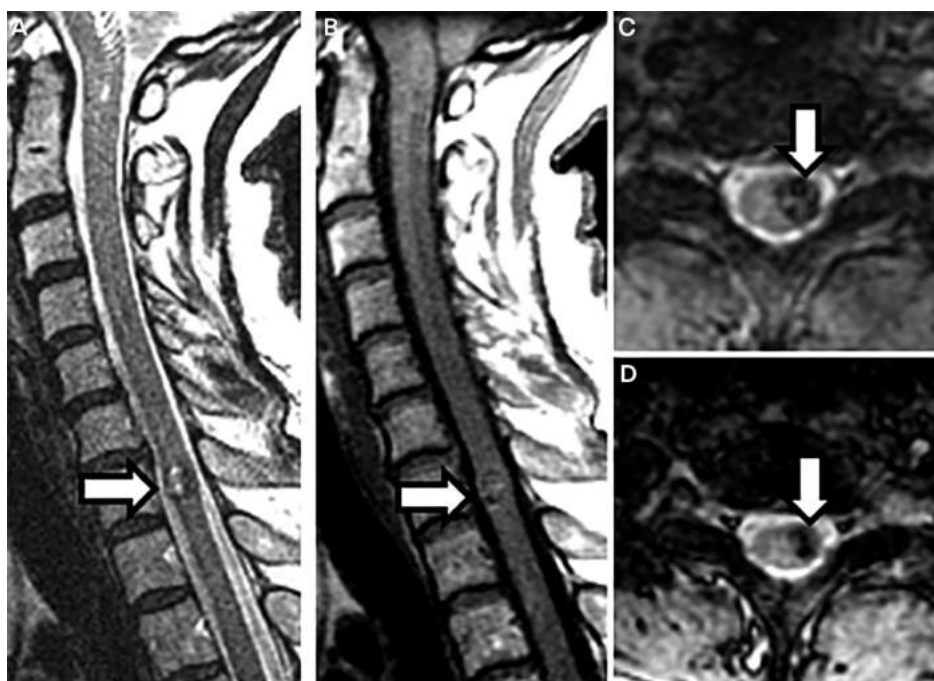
Imaging of the patient in CASE 2-3. Sagittal T2-weighted (A) and T1-weighted (B) MRI of the cervical spine shows hematomyelia with mixed T2 hypointensity (A, arrow) and T1 hyperintensity (B, arrow). Corresponding axial T2-weighted images (C, D) show a well-demarcated T2-hypointense rim (C, arrow; D, arrow) around the masslike lesion, typical of intramedullary spinal cord cavernous malformation.
